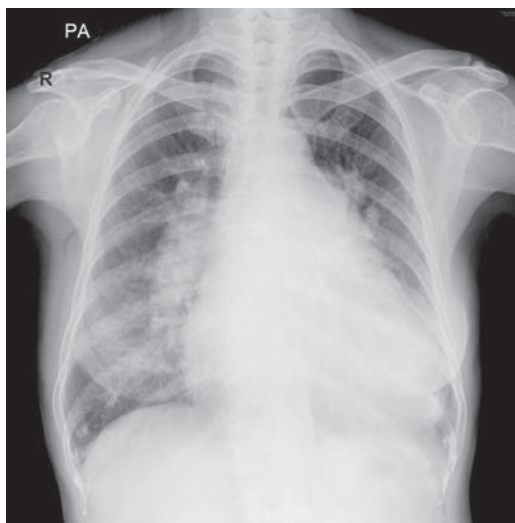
Chest X-ray in Eisenmenger complex. Note that the findings are those of pulmonary artery hypertension, i.e. cardiomegaly, prominent pulmonary arterial segment, large main pulmonary arteries and their branches and hilar area plethoric and lung periphery oligemic. Abbreviation: PA, pulmonary artery.
